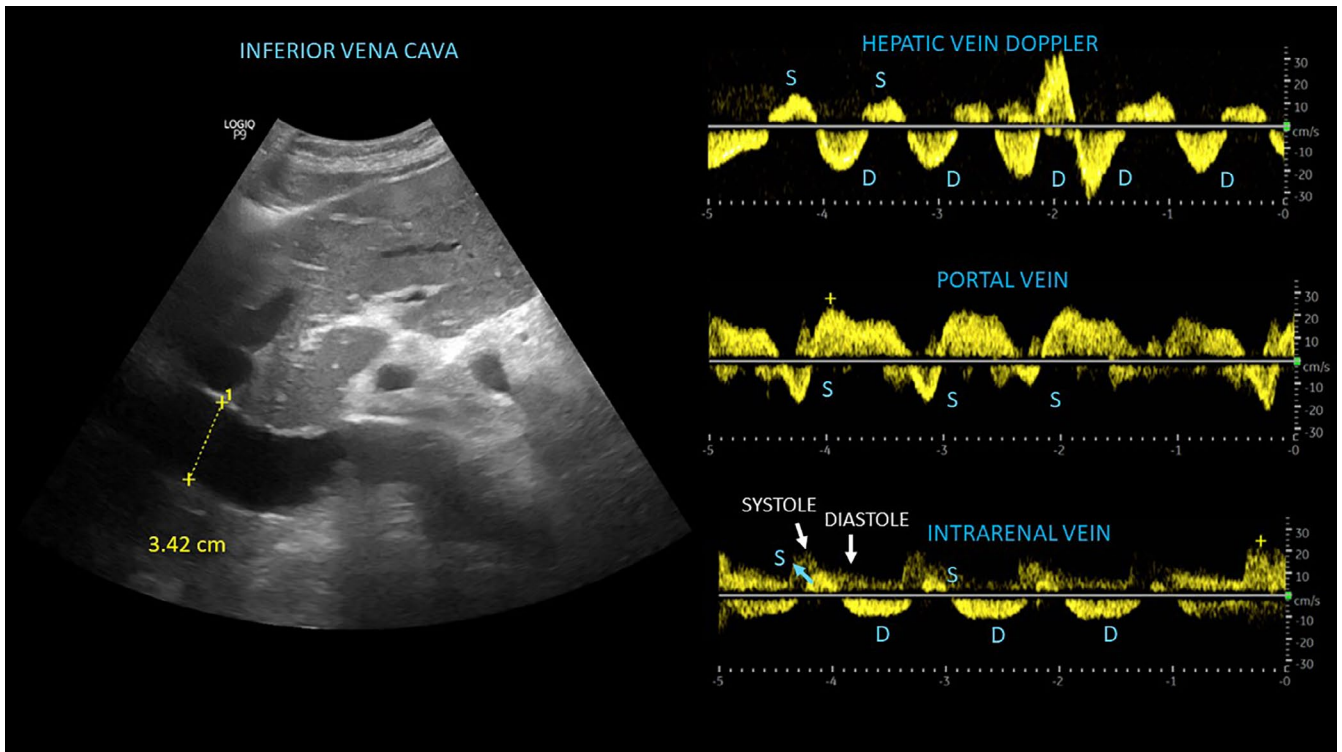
Inferior vena cava ultrasound and venous Doppler patterns from the index patient with pulmonary hypertension. S = systolic wave, D = diastolic wave. Note there is systolic flow reversal in all the veins
